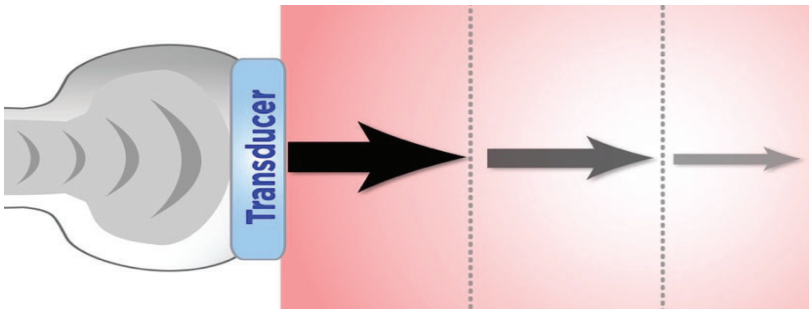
Attenuation of ultrasound across tissue planes.
